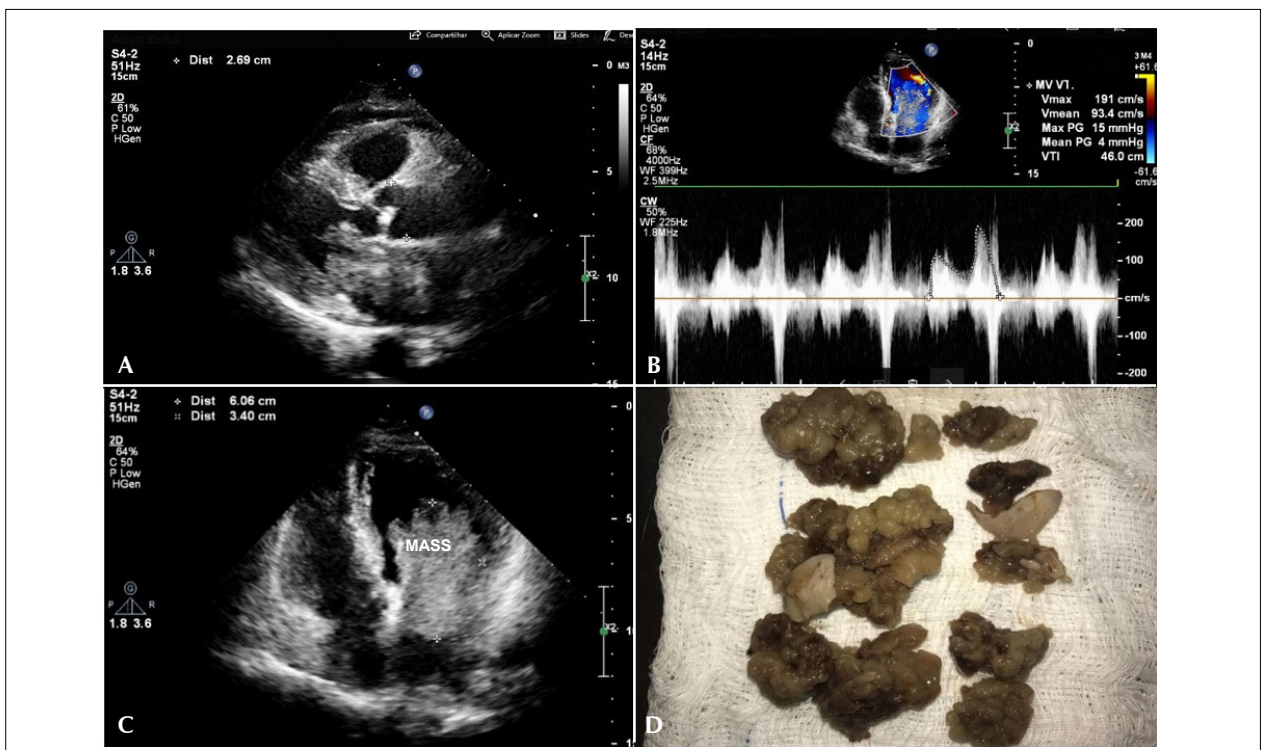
(A) A transthoracic echocardiogram taken in the parasternal long-axis view showing a mass adherent to the oval fossa. (B) A transthoracic echocardiogram showing obstruction of the left ventricular entry path. (C) A four-chamber apical transthoracic echocardiogram showing a left atrial mass with diastolic extension to the left ventricle suggestive of a myxoma. (D) A view of the cardiac myxoma after excision.
